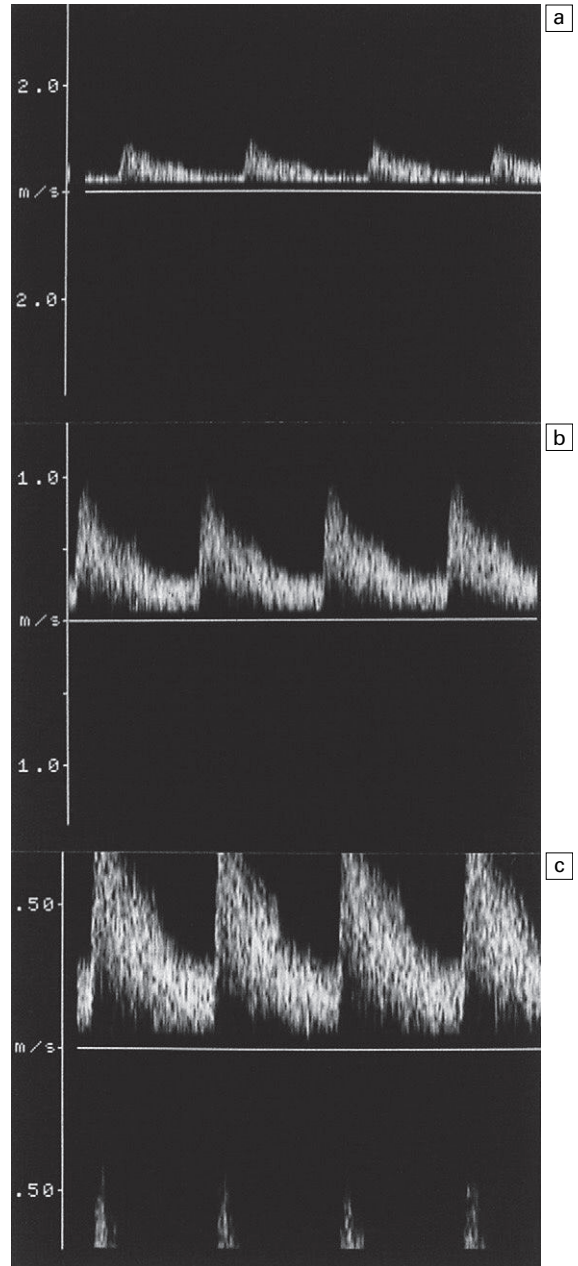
Aliasing in a sonogram. The highest velocities in (c) appear in the reverse channel.
